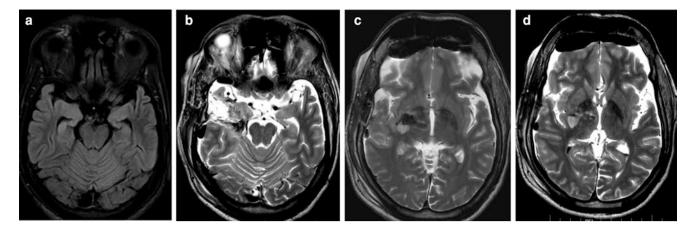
In a 31-year-old man with a long history of focal seizures, preoperative magnetic resonance imaging (MRI) showed atrophy of the right hippocampus with signal changes suggestive of mesial temporal sclerosis (a). Anterior temporal lobectomy with amygdalohippocampectomy was done, but left-side hemiplegia was noted immediately
